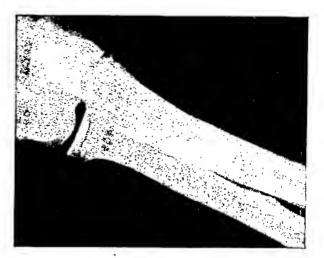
Case VIII. Aleukemic lymphatic leukemia. Roentgenogram of the left elbow showing thickened cortex of the ulna and circumscribed areas of bony proliferation, obliterating a part of the medullary cavity. R.K., male, aged sixty-seven (No. 252020). Aplastic type of anemia for five years, joint pains, hematuria, lymphadenopathy, splenomegaly. Sternal biopsy shows numerous lymphoblasts. Red blood cells 2.8 million, hemoglobin 40 per cent; white blood cells 3,800 with 46 per cent neutrophils, 2 per cent eosinophils, 50 per cent lymphocytes, 2 per cent lymphoblasts. No autopsy.
